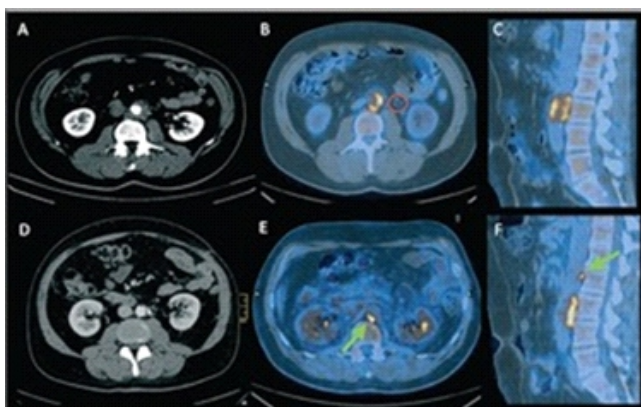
A 43 year old man with cramp-like abdominal pain and presence of peri-aortic solid tissue in the infrarenal section and locoregional lymph nodes interpreted as lymphomatous tissues. Baseline ^{18}F -FDG-PET/CT: uncommon uptake in solid periaortic tissue and locoregional lymph node. Laparoscopic biopsy PET/CT guided suggestive for IRF and following corticosteroid therapy. Post corticosteroid therapy ^{18}F -FDG-PET/CT: size reduction of the solid tissue [27].
